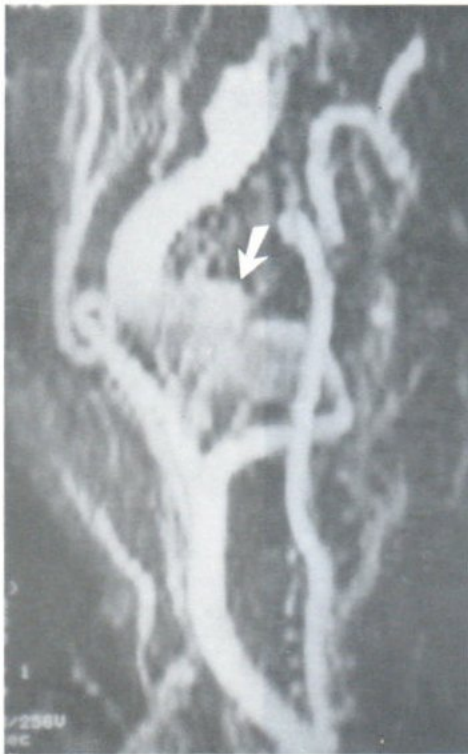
A MRI lateral view
